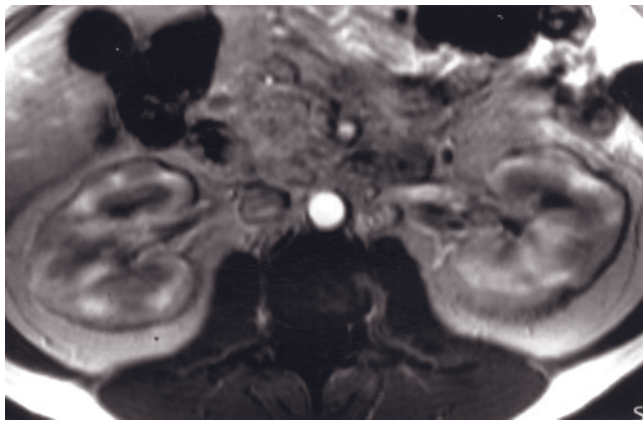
Small-vessel disease. T1-weighted precontrast (a) and immediate postgadolinium (b) fat-suppressed SGE images. Loss of corticomedullary differentiation in the left kidney is apparent on the precontrast image (a), consistent with diminished renal function. On the immediate postgadolinium image (b), multiple small cortical defects due to small-vessel disease are present. T1-weighted immediate postgadolinium SGE images (c, d) in a second patient demonstrate bilateral small, irregular renal cortical defects.
